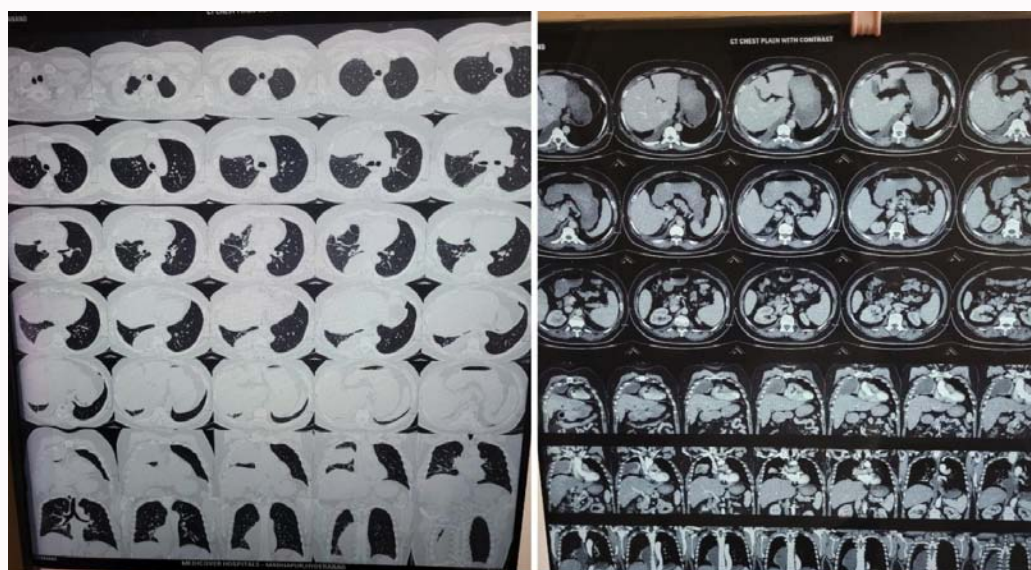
(B): CT chest plain with contrast.
